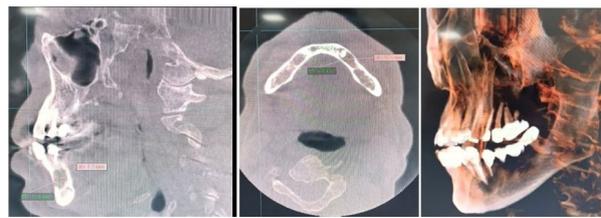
The mesio-distal, bucco-lingual, and antero-posterior size and 3D image of the lesion on CBCT.
